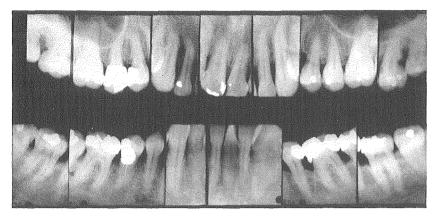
The roentgenograms show bone loss.
